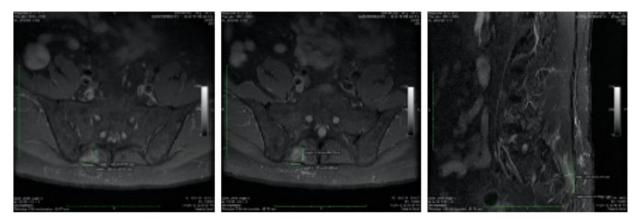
Post-procedure MRI demonstrating validation of lesion size and shape (left, middle, right).
